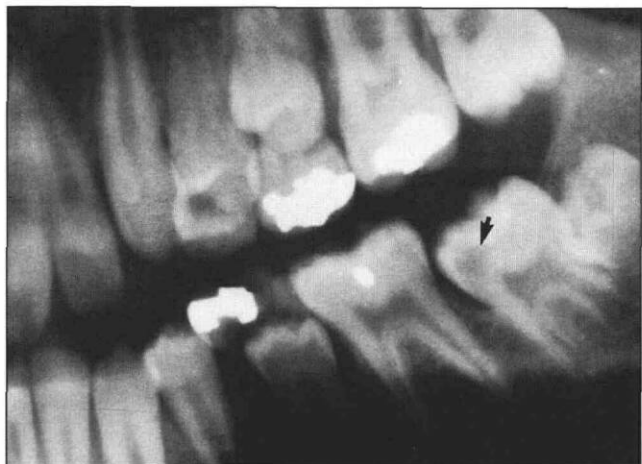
Radiograph showing an unerupted second mandibular permanent molar with a radiolucent area (arrow) located in the coronal dentin, under the mesial cusps.
